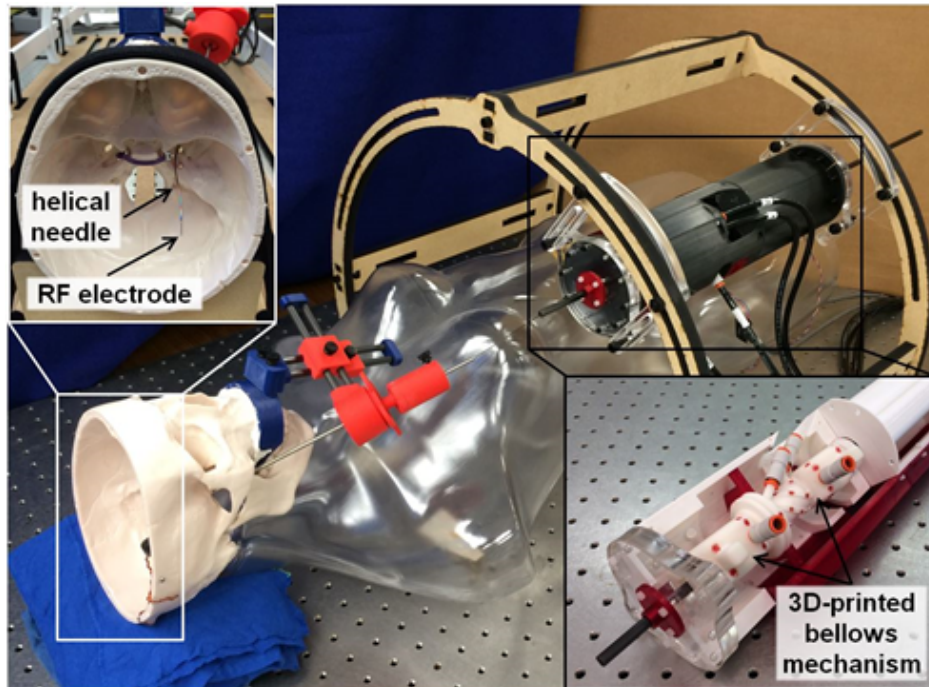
MRI-compatible robot actuation unit prototype in benchtop mockup of transforaminal ablation procedure.
